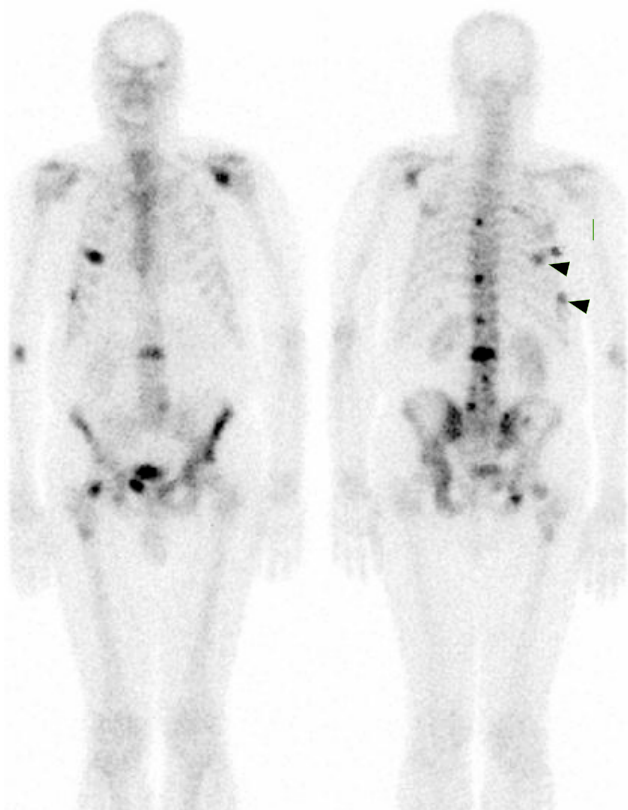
Whole-body bone scintigram demonstrates secondaries at multiple sites. Faint diffuse increased uptake is visible in the left hemi-pelvis. Arrowheads point to the known rib fractures, which cannot be differentiated from bone metastases
